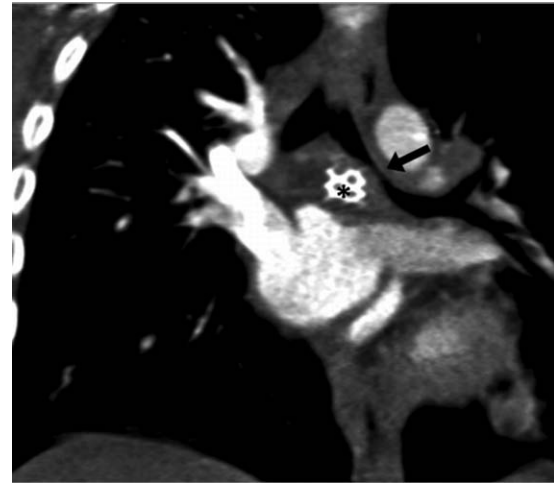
Chest radiography. Chest radiography shows reduced blood flow to the left lung. Stent in left pulmonary artery (asterisk).
